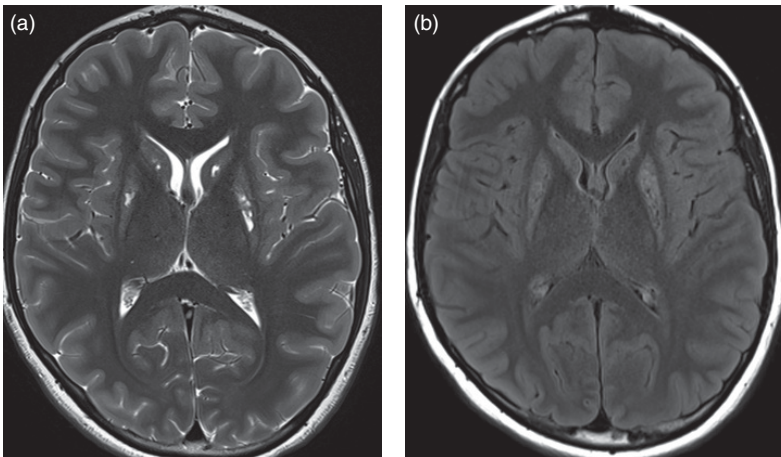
Biotin–thiamine responsive basal ganglia disease at 12 months. (a) Axial T2 and (b) FLAIR images demonstrate bilateral striatal necrosis. The patient had a history of paroxysmal episodes of weakness and ataxia responsive to a mitochondrial cocktail including biotin.
